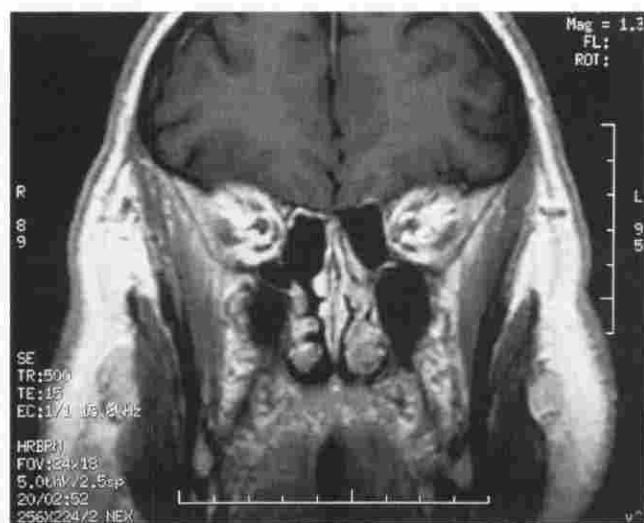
MRI showing no evidence of tumor recurrence at 4 years postoperatively.
